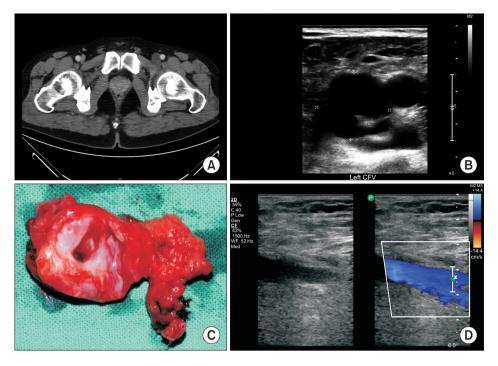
39-year-old male patient who suffered from left leg swelling was diagnosed with left femoral vein adventitial cystic disease and underwent left femoral vein cyst excision. (A) Preoperative computed tomography, (B) Preoperative duplex ultrasonography (DUS), (C) operative sampling photograph, (D) postoperative followup DUS.
